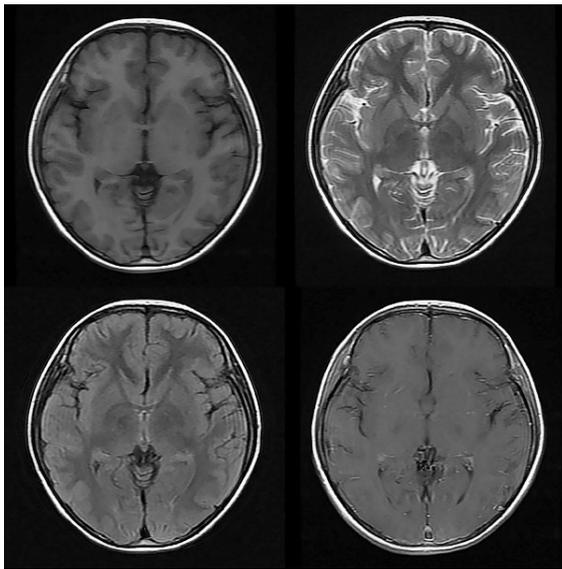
MR and enhanced MR imaging showing no obvious abnormality.
